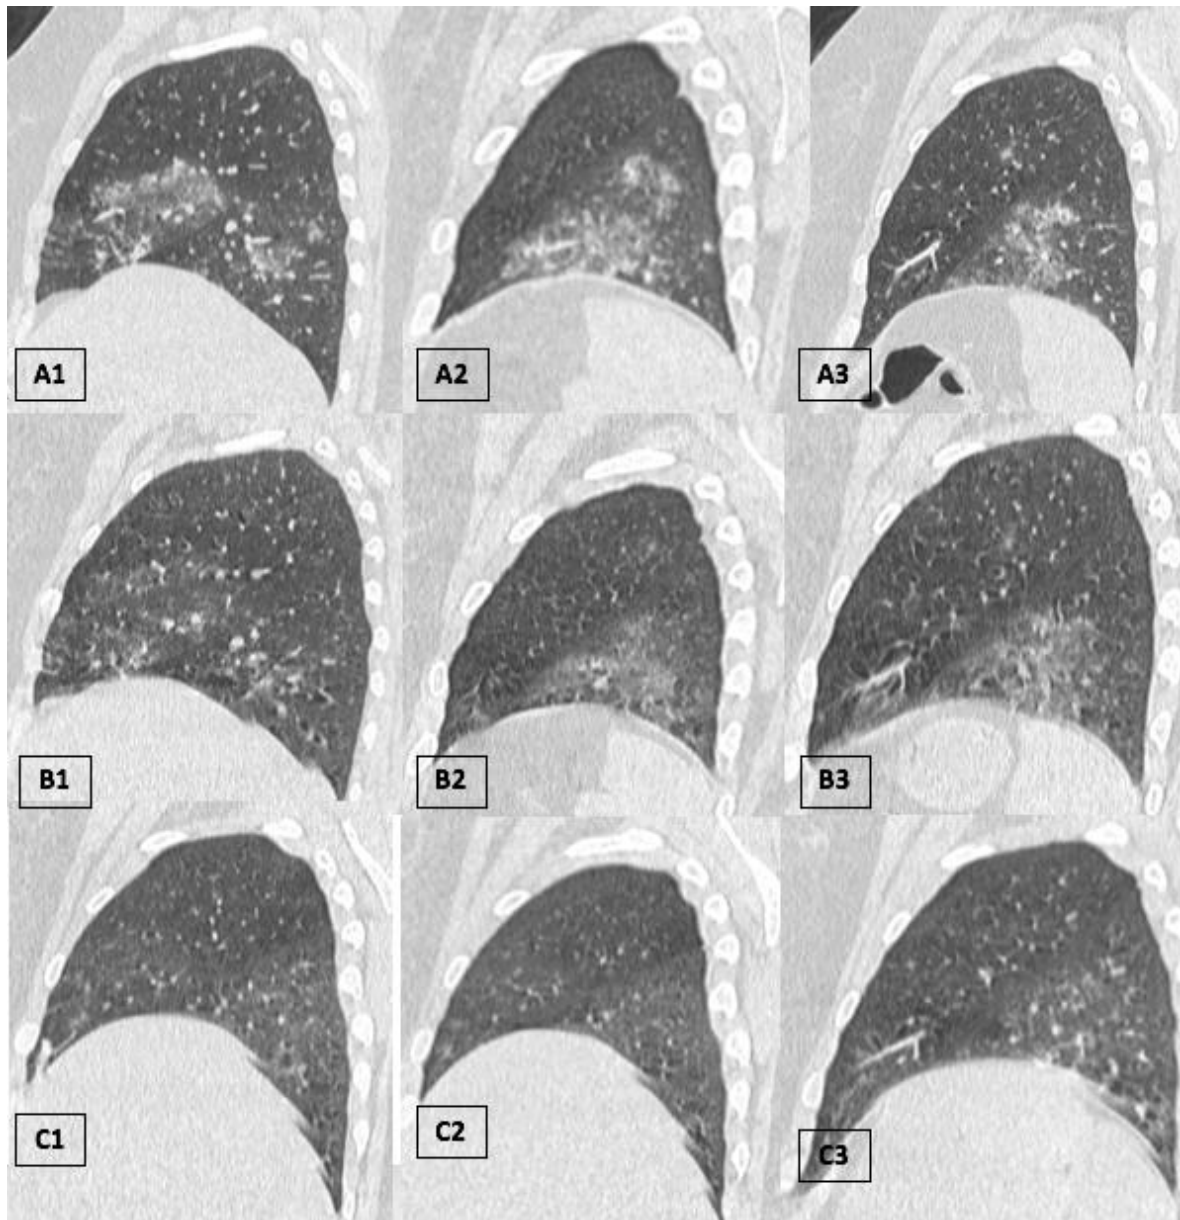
Sagittal non-enhanced lung sequences chest computed tomography at presentation in (A1,A2,A3) and control CT respectively after 4 days in (B1,B2,B3) and after 10 days in (C1,C2,C3) , all images have the same window level and window width : (A1,A2,A3) Bilateral diffuse ground glass opacities interesting the inferior lobes and the superior right lobe associated to a small consolidation areas . (B1,B2,B3 & C1,C2,C3) : progressive disappearance of lung abnormalities.
